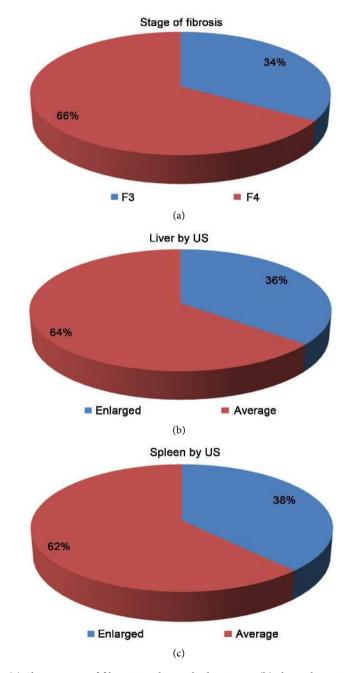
(a) Shows stage of fibrosis in the studied patients; (b) shows liver size by ultrasonography; (c) shows spleen size by ultrasonography.
